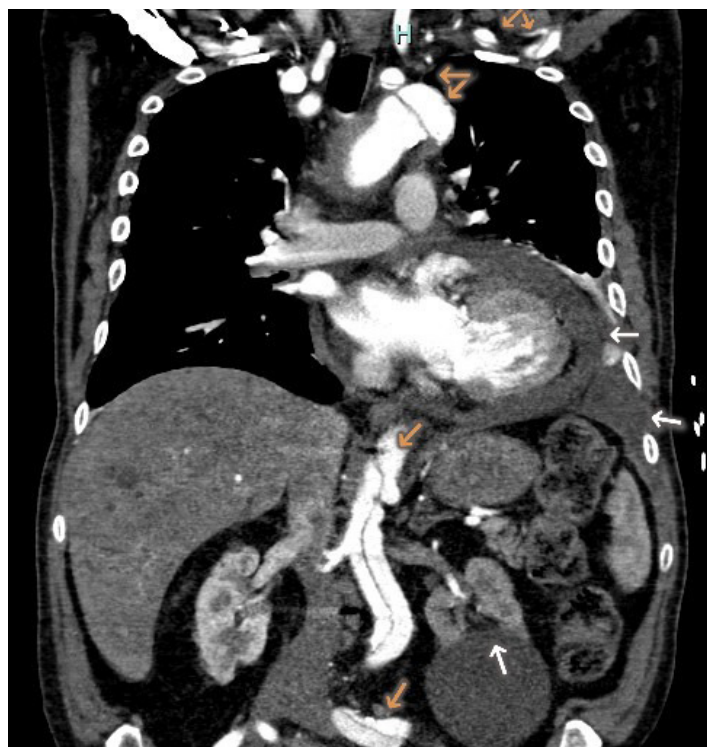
Computed tomography angiography image demonstrating an aortic root dissection extending to ascending aorta, left subclavian artery, descending aorta, and left iliac artery (yellow arrows). Circumferential pericardial effusion, left pleural effusion, and poor left renal perfusion were also noted (white arrows).
